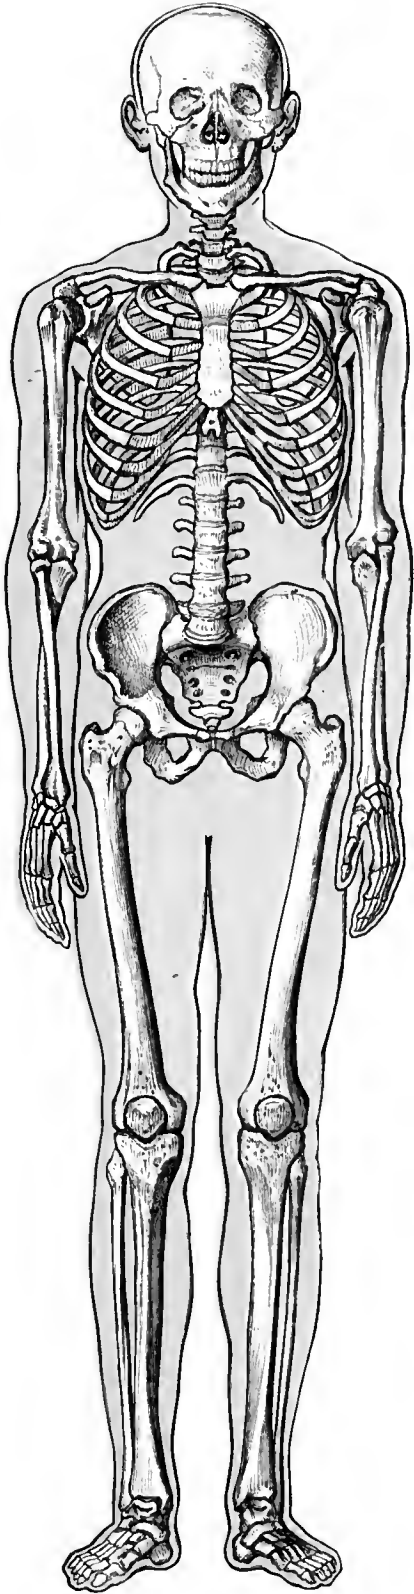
ANTERIOR ASPECT.
